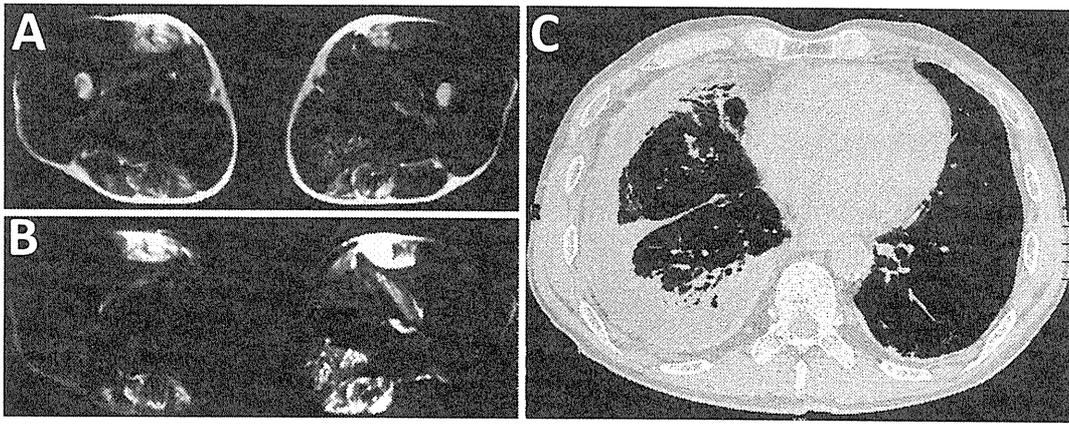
Magnetic resonance images of the thighs (A, B) and computed tomographic scans of the chest (C). T2-weighted (A) and T2-short-tau inversion recovery (STIR) images (B) showed diffuse high intensity in the frontal and dorsal aspects of both thigh muscles, suggesting intramuscular inflammation and edema. Chest images showed massive pleural effusion with interstitial lung disease (C).
